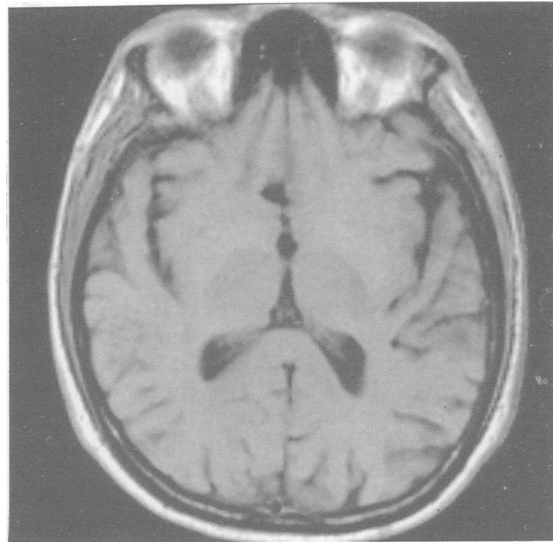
Six month follow up MRI. Axial T1 weighted image (TR/TE, 750/15 ms) at the same level as fig 1 is normal. The increased signal intensity has resolved secondary to the decreased concentration of Mn after physiological excretion.
